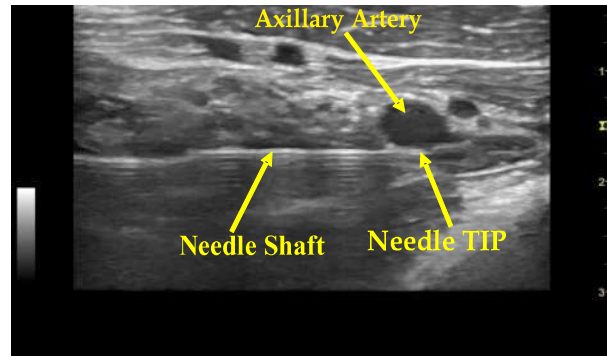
A transverse sonogram showing the axillary artery and needle shaft in RCB and angle of needle shaft is noted to be perpendicular
